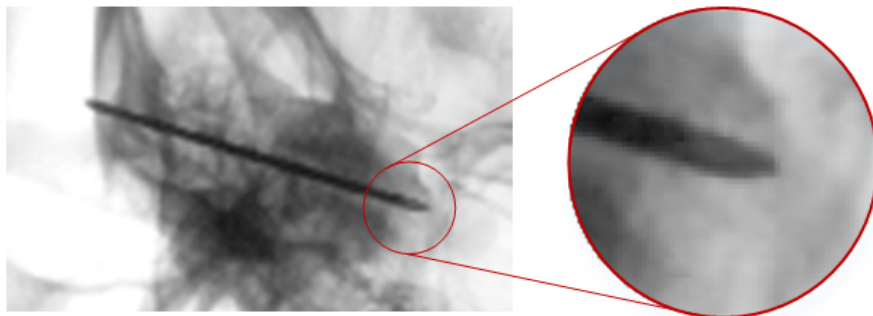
The appearance of the drill bit tip on an X-ray image.
